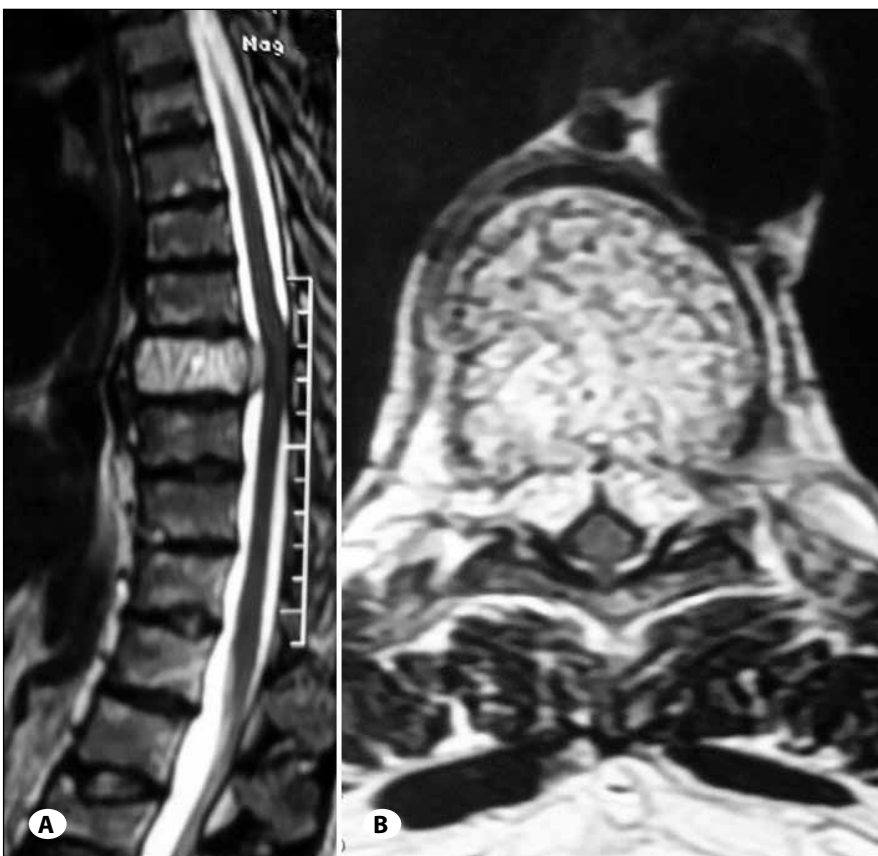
A) Magnetic resonance imaging of thoracic spine (sagittal view) with contrast showing T8 hemangioma compressing the anterior spinal cord. B) Magnetic resonance imaging of thoracic spine (axial view) showing T8 hemangioma encasing the spinal cord.
